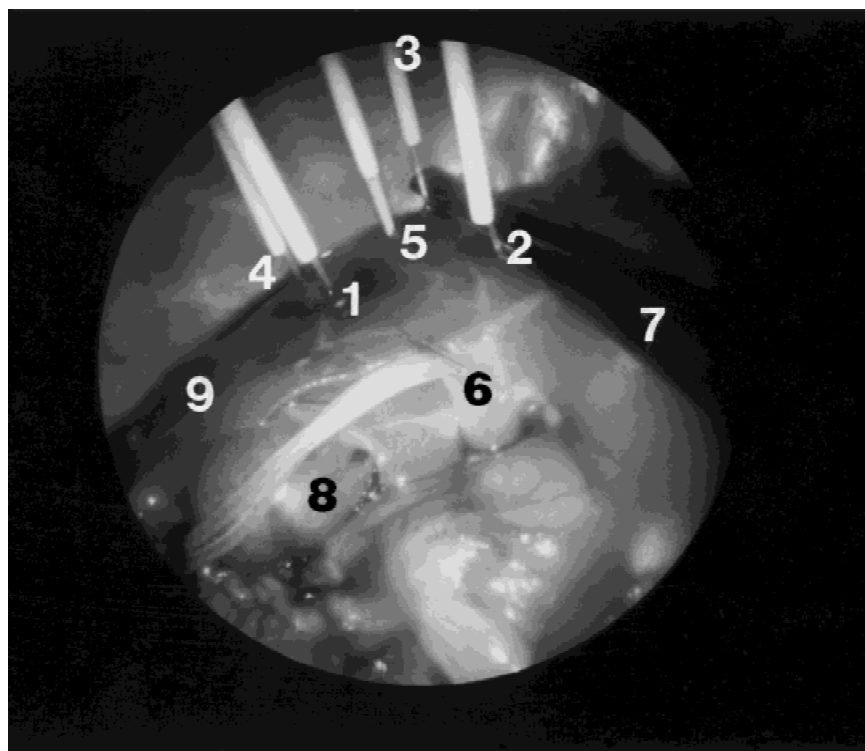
Intraoperative view during laparoscopy. Laparoscopic ultrasound scanner is placed on the liver surface between applicators. 1-4, Applicators; 5, thermocouple; 6, hepatoduodenal ligament is snared with a silicon loop; 7, ultrasound scanner; 8, gallbladder; 9, liver surface.
